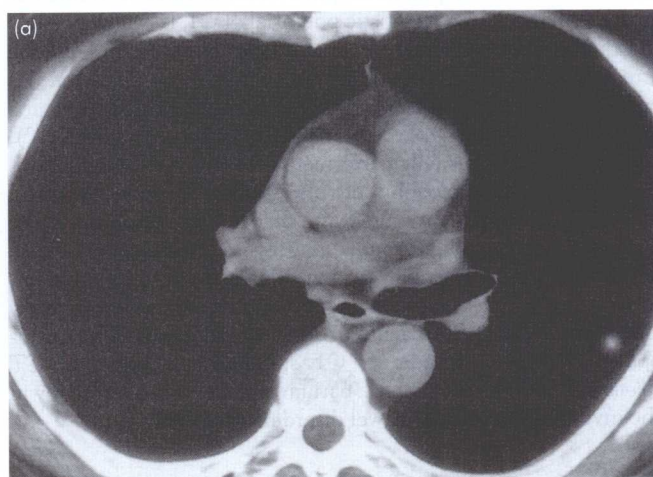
Computerised tomography (CT) scan. The effect of varying window width and level. (a) At soft-tissue settings (width 400 HU, level 40 HU) the normal mediastinal structures are shown. (b) At lung settings (width 1000 HU, level 700 HU) soft-tissue and bone detail is lost but the lung parenchyma is seen.
